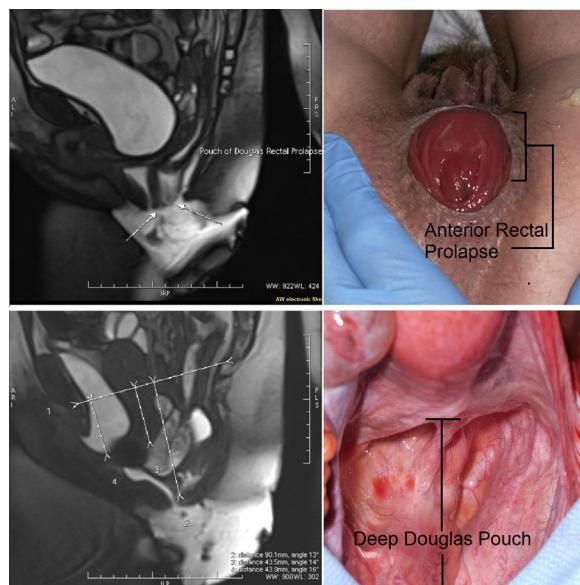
Example of rectal prolapse and deep Douglas pouch along with MRI findings.
